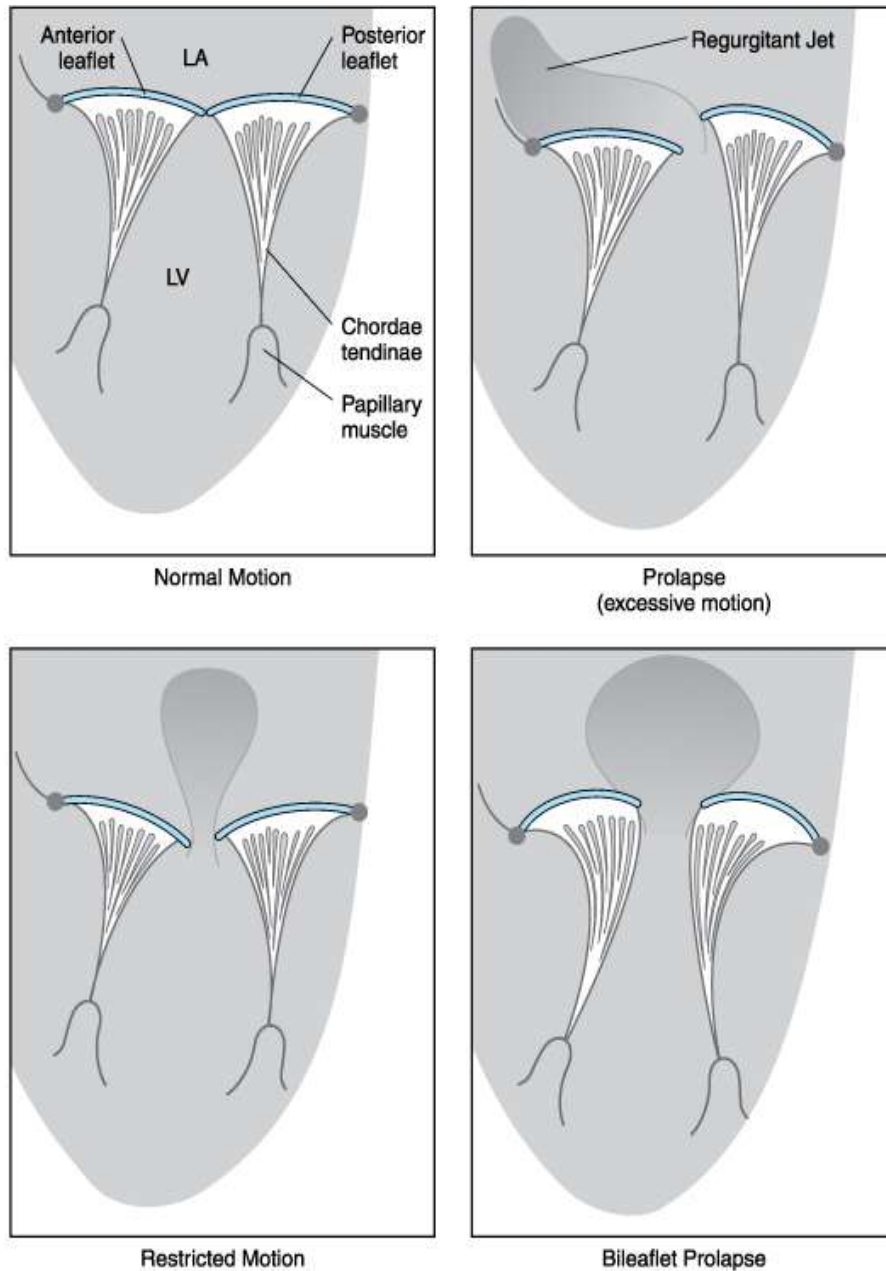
Classification of mitral valve leaflet motion (as seen from transesophageal echocardiography). Note that with prolapse, the free edge of the leaflet(s) extends beyond the plane of the mitral annulus producing an eccentric jet. With restricted motion, the leaflets fail to coapt resulting in a central jet (Morgan, 2006).
